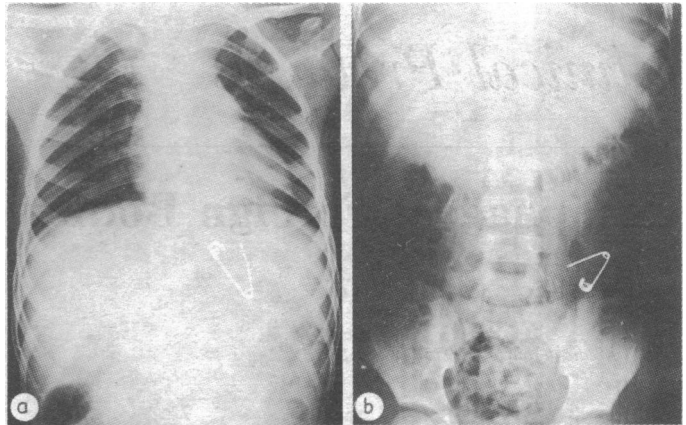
Plain films of chest (a) and abdomen (b) of a 7-year-old child who swallowed open safety pin showing migration of pin to stomach and intestines. Pin passed spontaneously from anal canal.
